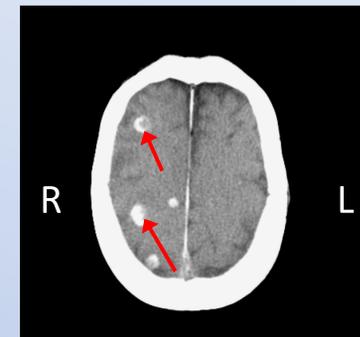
CT axial view of lesions (red arrows) in right cerebral cortex.
